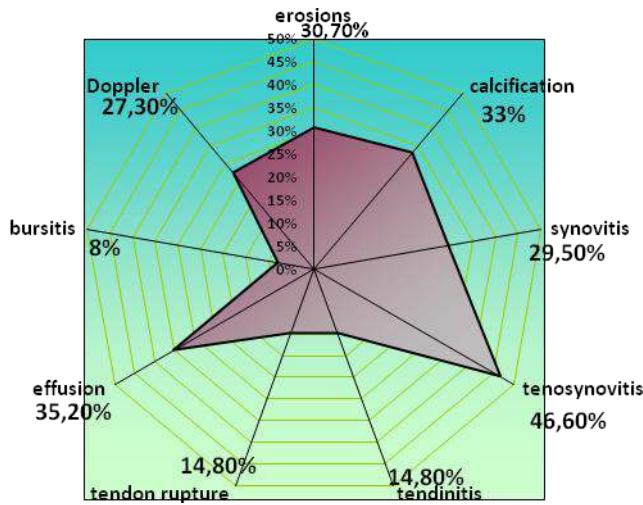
The main ultrasonographic changes observed in the patients studied
